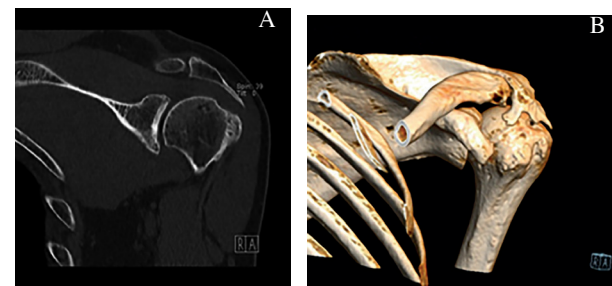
Postoperative computed tomography scan, 7 months after surgery: coronal plane (A) and 3D reconstruction (B), showed a rare ossification of the coraco-acromial ligament with a plate-shaped osteophyte formation originates from the acromion going antero-lateral, which makes this case special.
